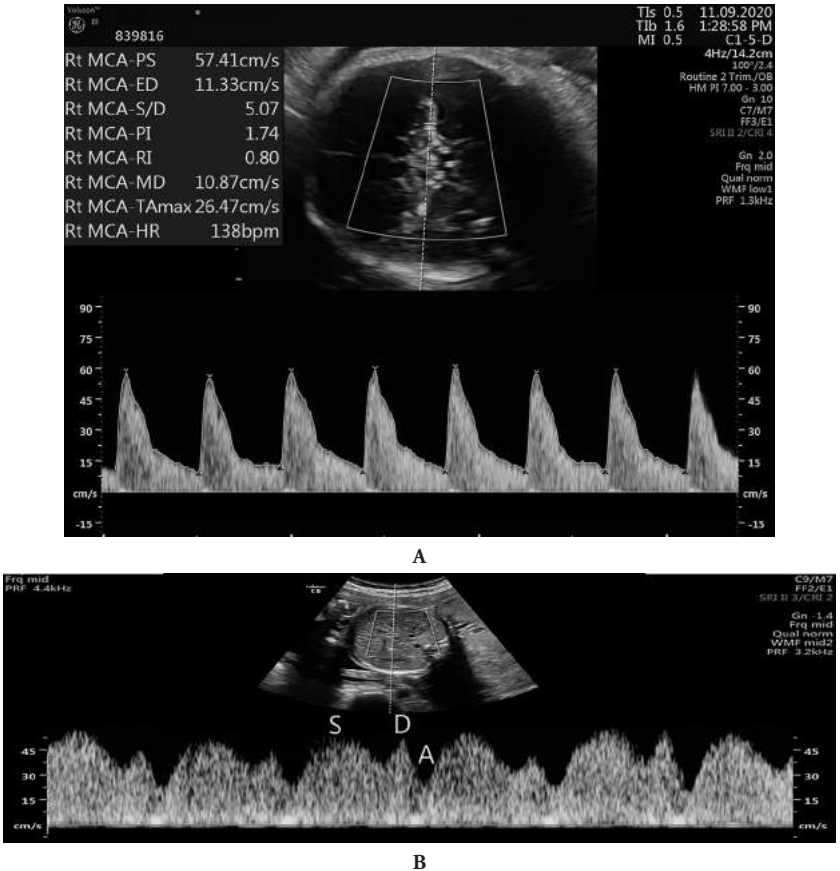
A: Ultrasound image of the fetal cerebral vasculature, with Doppler visualization of the middle cerebral artery and measurement of the peak systolic velocity. B: Doppler of fetal ductus venosus showing normal flow pattern. (S wave-ventricular systole, D wave-ventricular diastole, A wave-atrial contraction).
